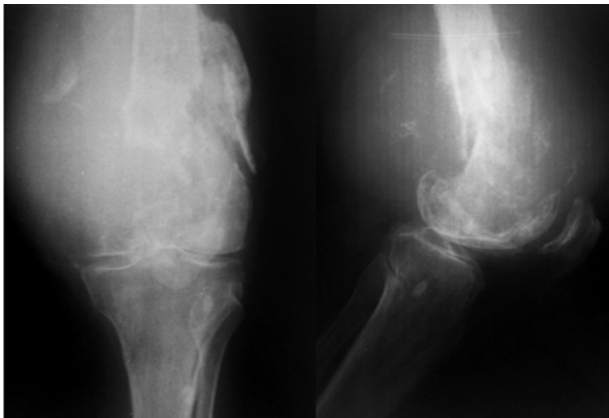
Preoperative radiographies of one of the study patients, diagnosed with GCT in the left distal femur.
